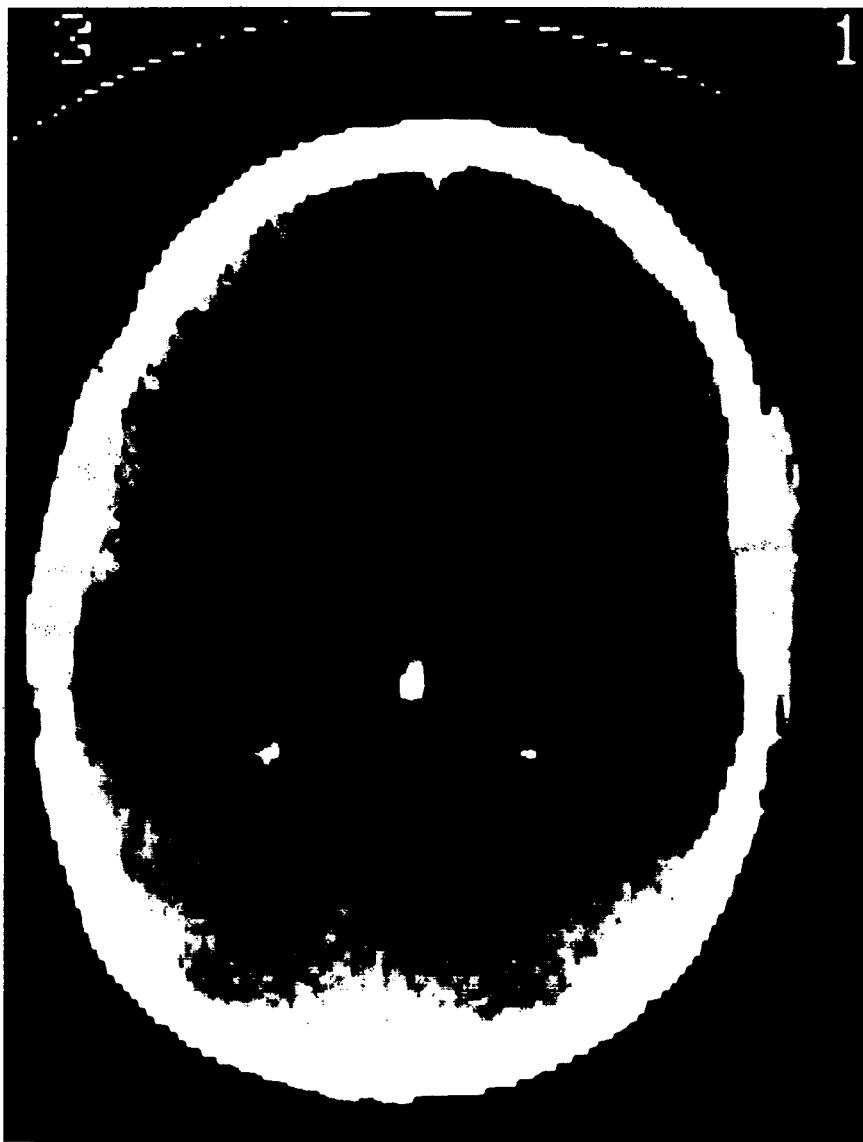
A representative CT scan showing bilateral temporal lobe infarction. (By courtesy, Dr Sage.)
